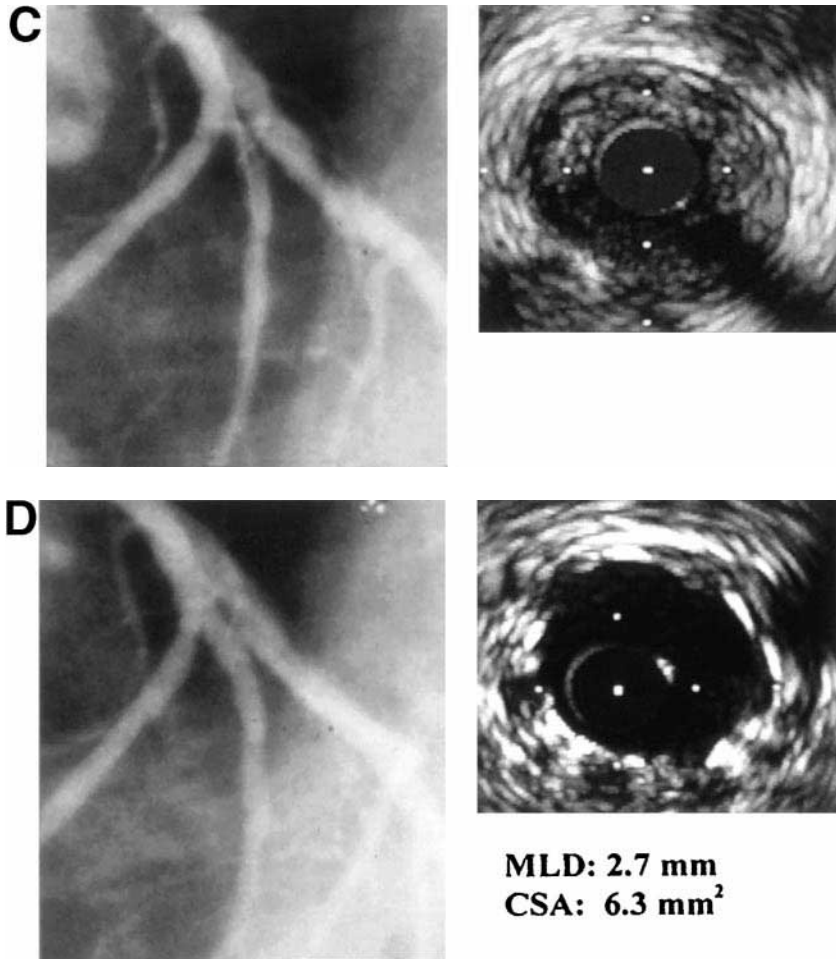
The tight stenosis shown (A) measured 0.3 mm by QCA with a reference diameter measurement of 1.7 mm. Based on this measurement, an aggressive balloon size was chosen at 2.5 mm diameter, which was expanded to 16 atm. The angiogram following the initial angioplasty (left) is shown (B) along with the IVUS image (right). The angiogram shows a successful angioplasty result, and although there is some haziness around the lumen, the boundary shows complete effacement of the stenosis. The corresponding ultrasound image reveals that the lumen size has enlarged to 1.5 mm in diameter; however, the vessel diameter from media to media is much larger than expected at 3.4 mm. The large amount of plaque distributed uniformly throughout the length of the vessel forces QCA to underestimate the true size of this large diagonal branch. Based on the IVUS assessment of vessel diameter, a 3.5-mm balloon was chosen and expanded to 10 atm.
